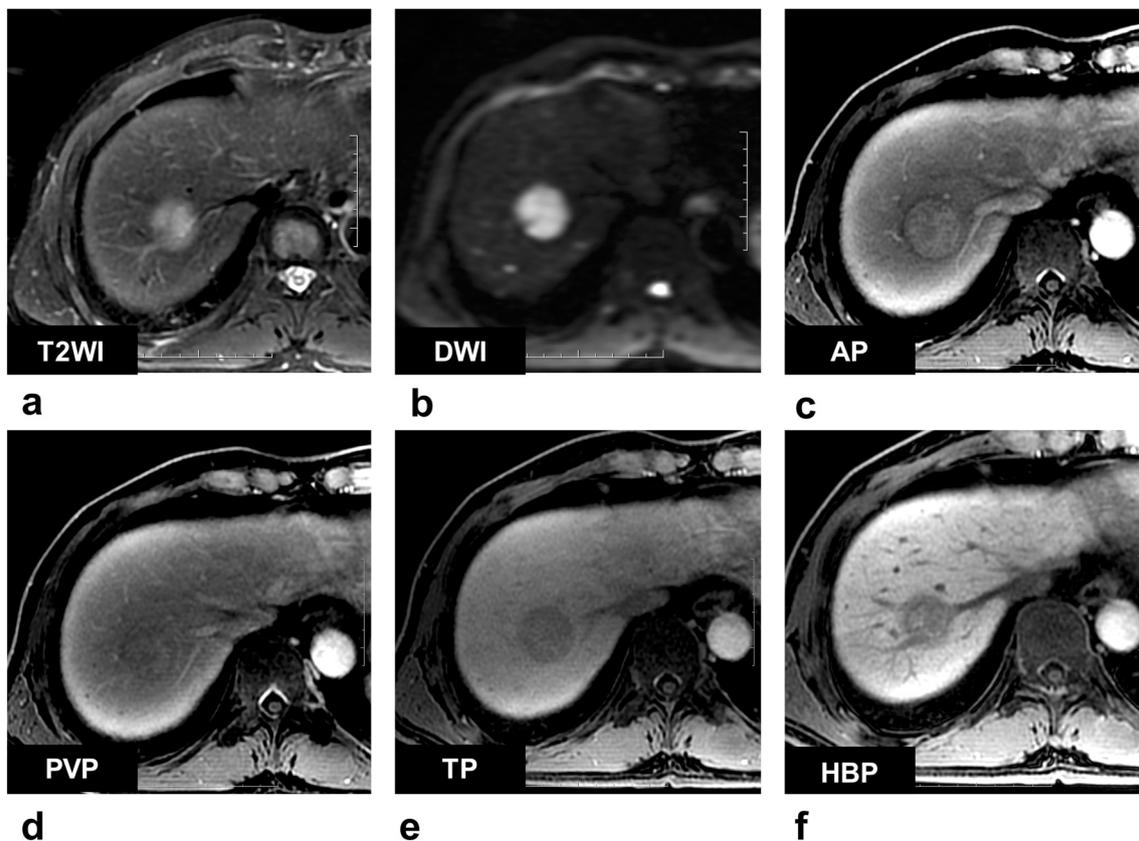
A 56-year-old man with hepatocellular carcinoma underwent gadoteric acid disodium-enhanced liver MR images. The T2WI (a) showed a slightly hyperintensity tumor on the right liver lobe, the DWI (b) showed markedly diffusion restriction. The single arterial phase (c) image showed typical enhancement pattern of “wash-in” and the portal venous showed “wash-out” (d), the equilibrium phase (e) and hepatobiliary phase showed hypointensity. Arterial phase (AP), diffusion weighted imaging (DWI), equilibrium phase (EP), hepatobiliary phase (HBP).
